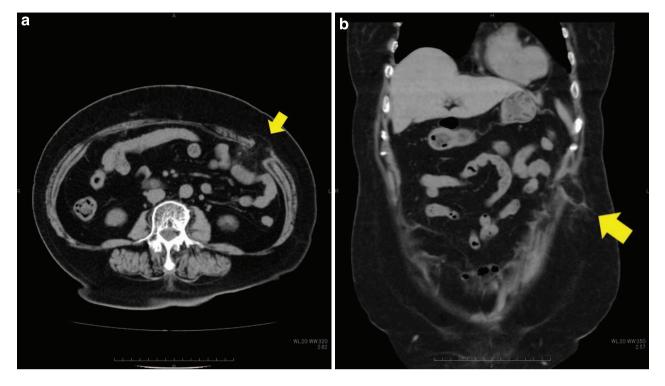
Diagnosis of a trocar site hernia on CT. The arrow indicates the defect. (a) Axial section. (b) Coronal section.
